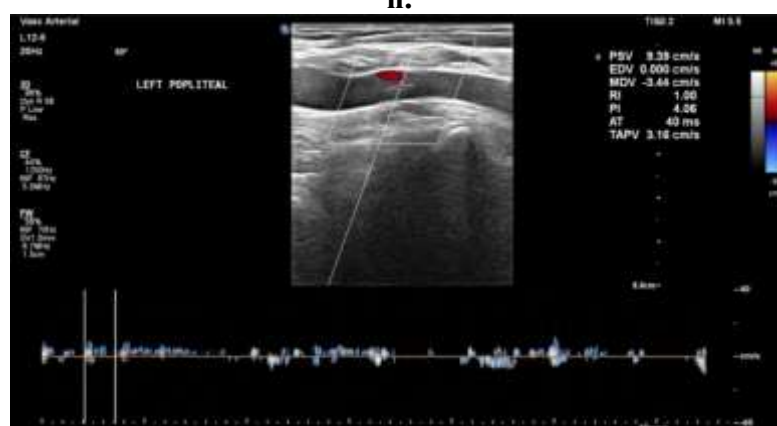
Image n. Color doppler and Spectral waveform of longitudinal section of left popliteal artery showing absent color flow and low velocity monophasic waveforms.
